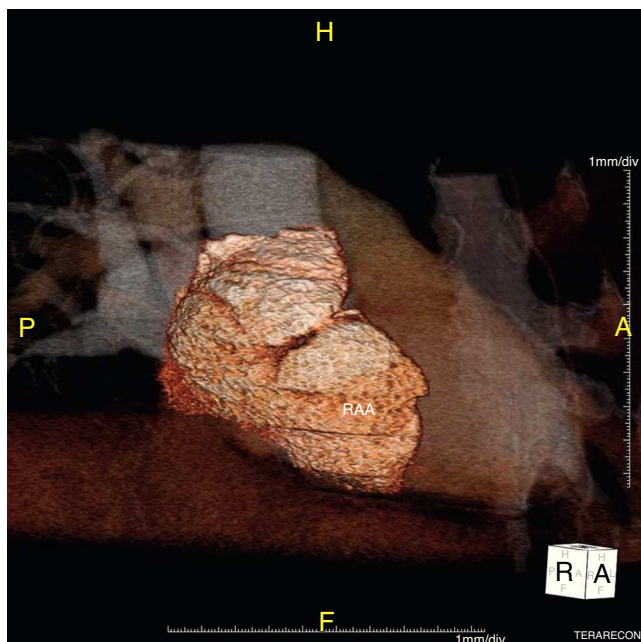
CT scan: three-dimensional reconstruction of the right atrial aneurysm (RAA).
